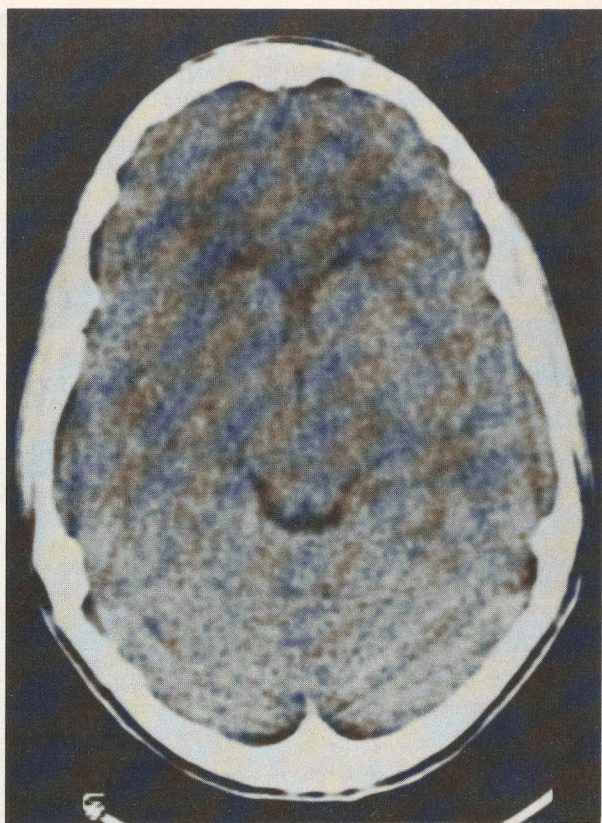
Initial noncontrast computed tomographic brain scan, which is essentially normal.
